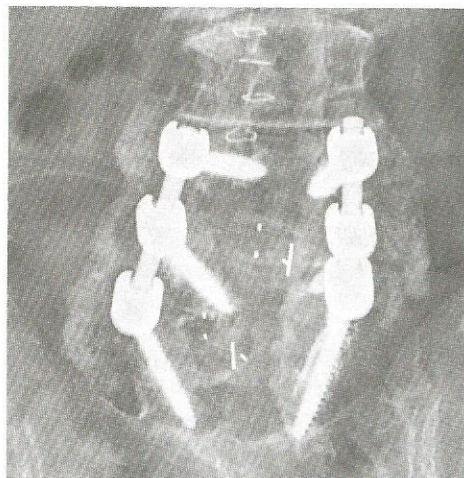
Three-month X-ray showing expansion of mineralization process within VESUVIUS Fibers allograft
